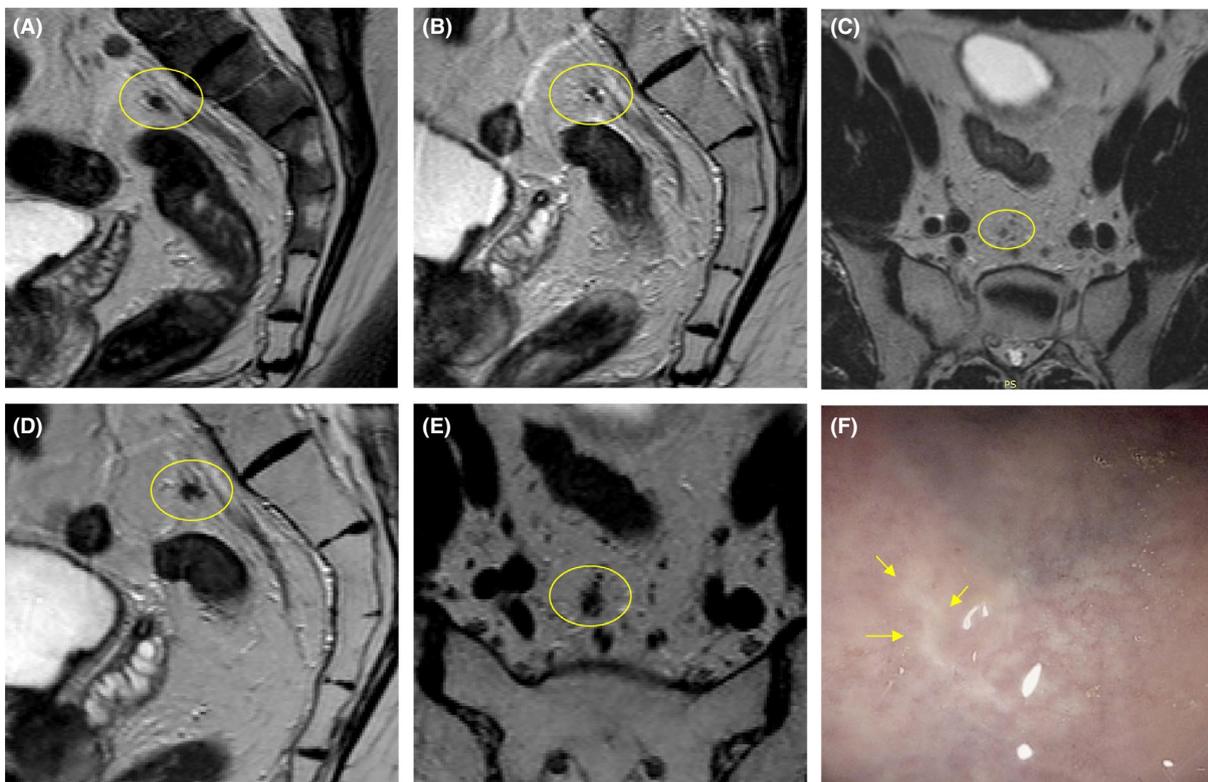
Example of a patient with rectal cancer with a malignant lymph node on (A) sagittal T2-weighted MR images before chemoradiation treatment. After chemoradiation treatment (B), (C) the lymph node decreased in size and was considered as no longer suspect. 12 months later (D), (E) the lymph node has grown, suggestive of nodal regrowth, while maintaining a luminal complete response on endoscopy (yellow arrows) (F)
